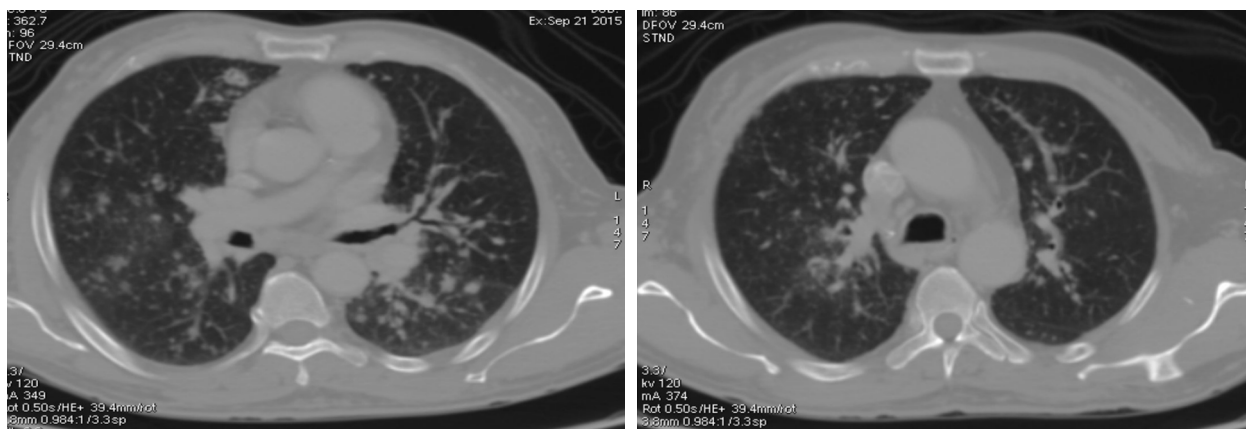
High resolution computed tomography of chest
